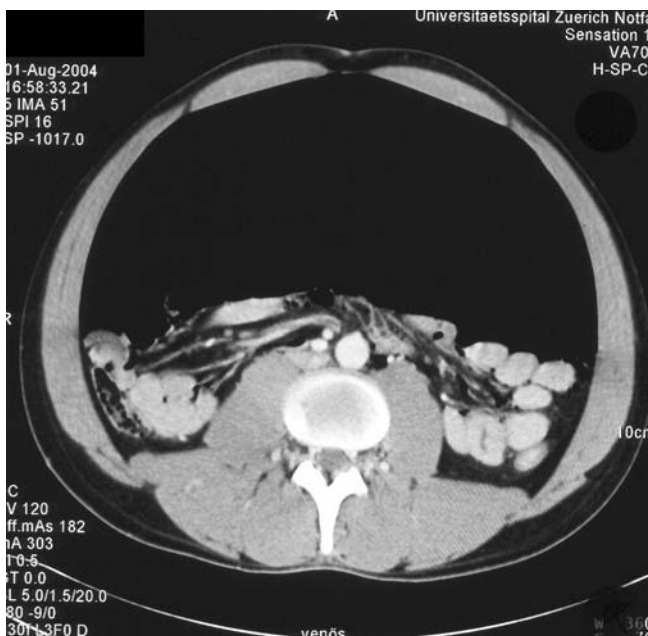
Computed tomography of inferior abdomen with an extended pneumoperitoneum and compression of the gastrointestinal tract
